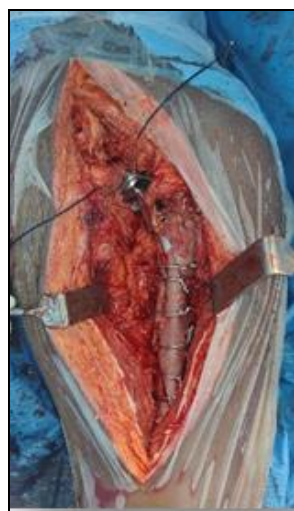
Prosthesis placement and cable fixation, Fig 5: Post op Xray
